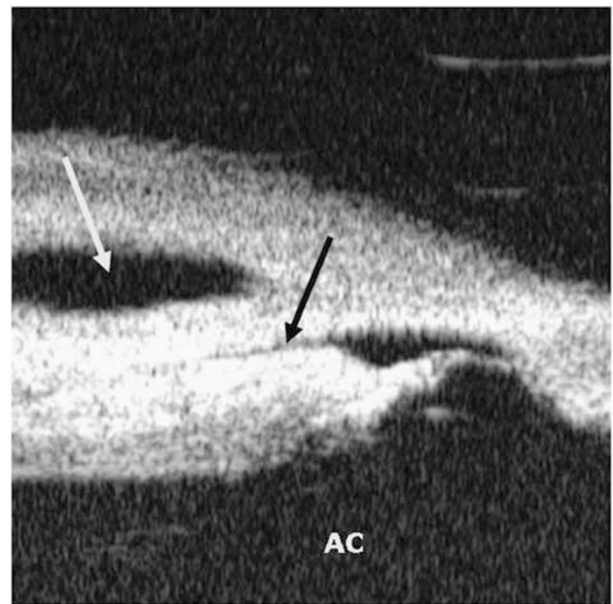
Ultrasound biometry of the bleb showing subconjunctival drainage (white arrow) and an underlying suprachoroidal cyclodialysis cleft (black arrow).
